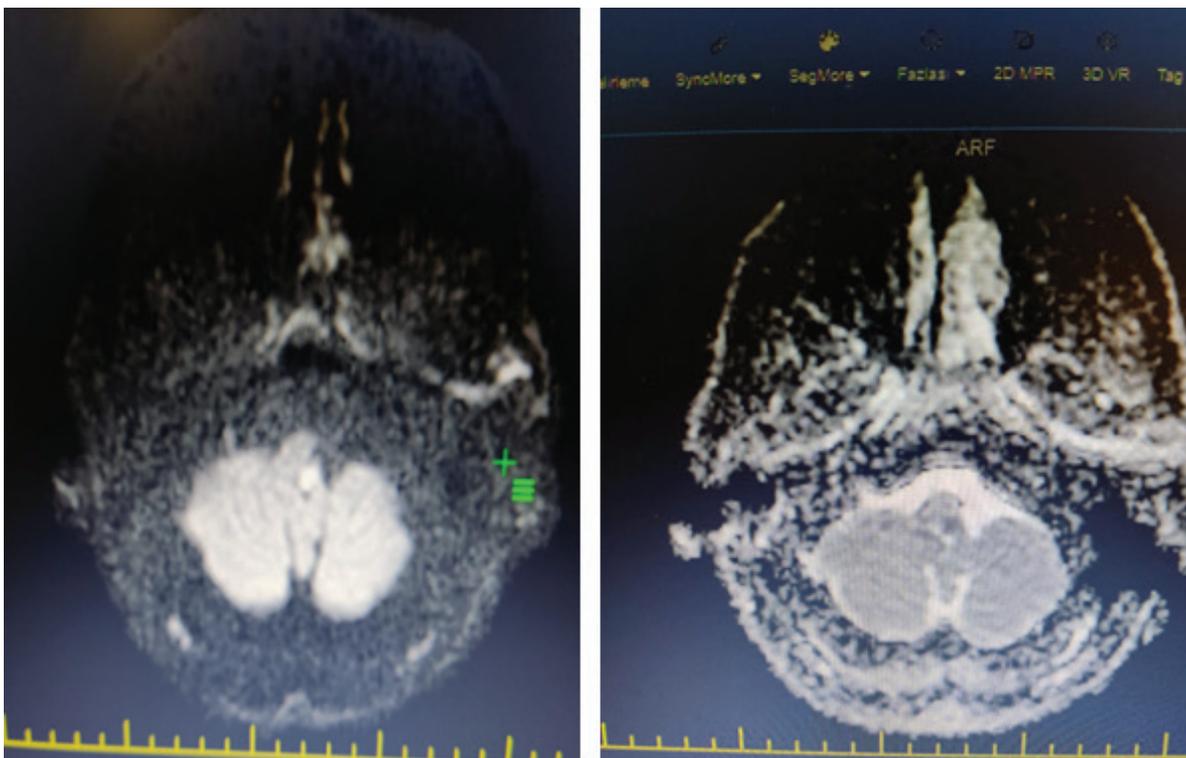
Brain MRI scan detected a left cerebellar infarction
